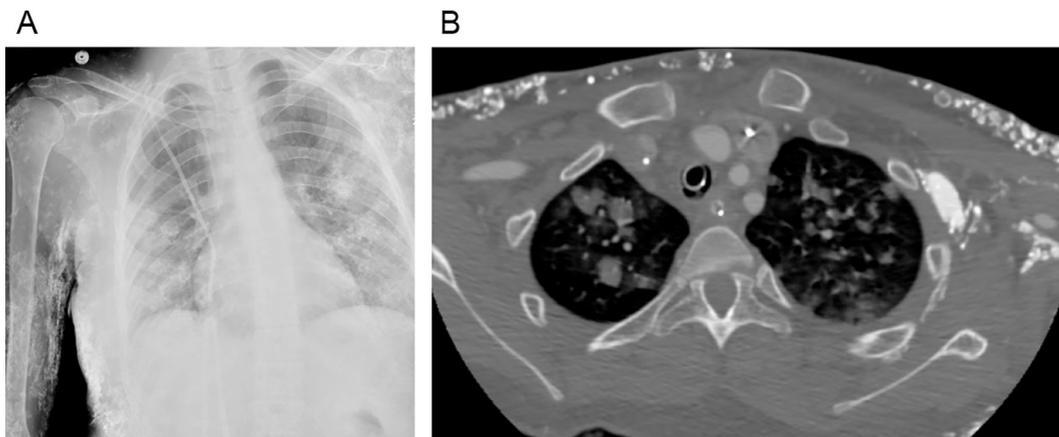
Extensive muscular and soft tissue calcifications in a patient with dermatomyositis on radiograph of the chest (A) and contrast enhanced CT (B). Calcifications in this condition are more extensive and can also be seen in the subcutaneous fat and other soft tissue in contrast to rhabdomyolysis.
